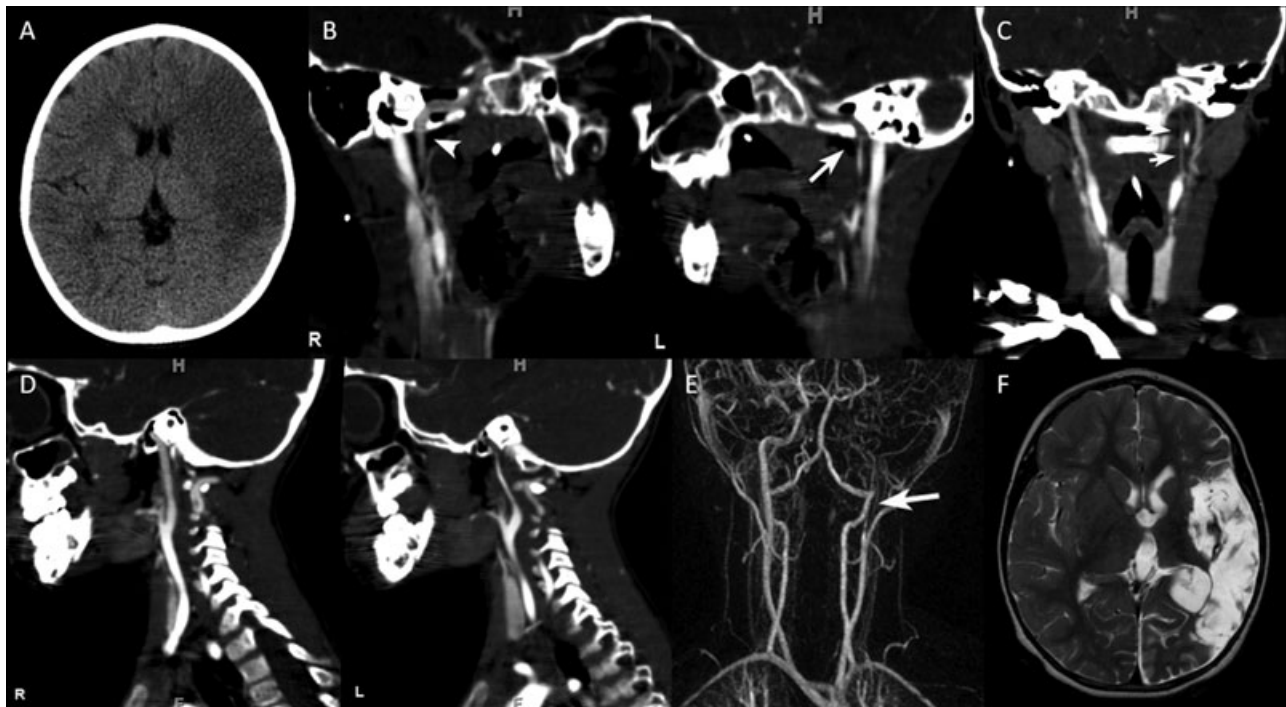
Axial CT (A), multiplanar CT-angiography (B–D), follow-up coronal MR-angiography (E) and axial T2-weighted (F) MR images of a male infant with posttraumatic left internal carotid artery dissection. The child had presented with an acute right focal neurological deficit. CT shows a large subacute, hypodense left middle cerebral artery infarction. CTA show an acute dissection with tapering of the left ICA with complete occlusion of the left ICA at the level of the skull base. Follow-up MRA and MRI show the occluded left intracranial ICA and the chronic left MCA ischemia.
